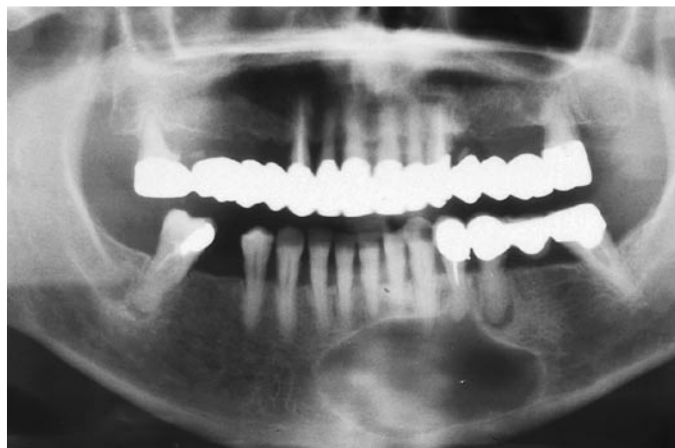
In this case, in view of the lesion's extensiveness, a panoramic radiograph was obtained to visualize the limits of the radiolucency.
